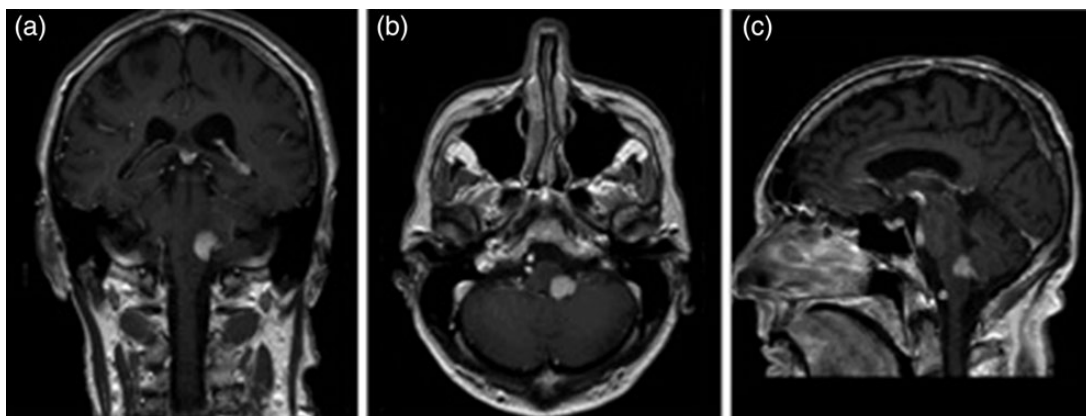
Gadolinium-enhanced T₁-weighted MRI images (panes lettered with coronal (a), axial (b) and sagittal (c) sections) showing a homogenous enhancement of a clearly demarcated lesion in the left posterior and lateral midbrain with extension into the inferior cerebellar peduncle.
